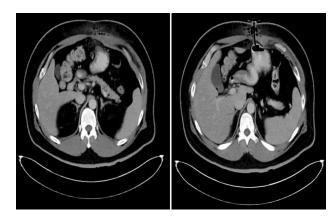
A patient with necrotizing fasciitis secondary to infected PEG. CT Abdomen/Pelvis demonstrating air in the subcutaneous tissue as well as the anterior sheath of the abdominal wall with inflammatory changes in a patient 1 week after PEG insertion.
